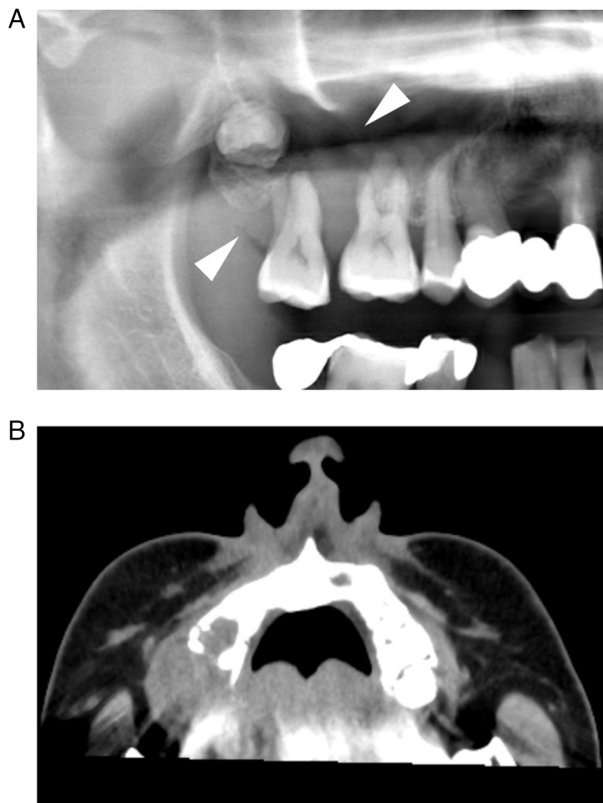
Radiographic appearance of metastatic maxillary gingival lesion. (A) Panoramic radiography showing bone resorption of the affected area (arrow head). (B) Computed tomography image showing bone destruction and a mass formation of the right side of maxilla.
